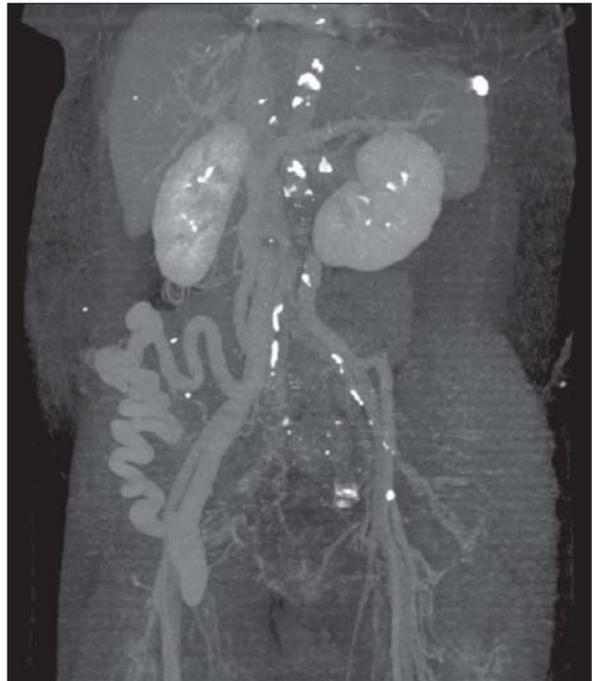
CT angiogram showing a dilated superior mesenteric vein and a large communicating vein connecting to the femoral vein.
